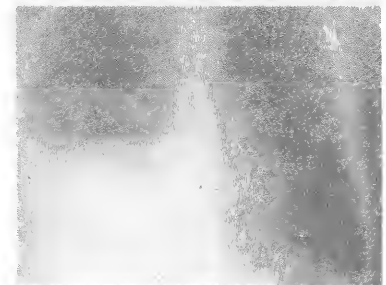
Chest X-ray of a subphrenic abscess:
